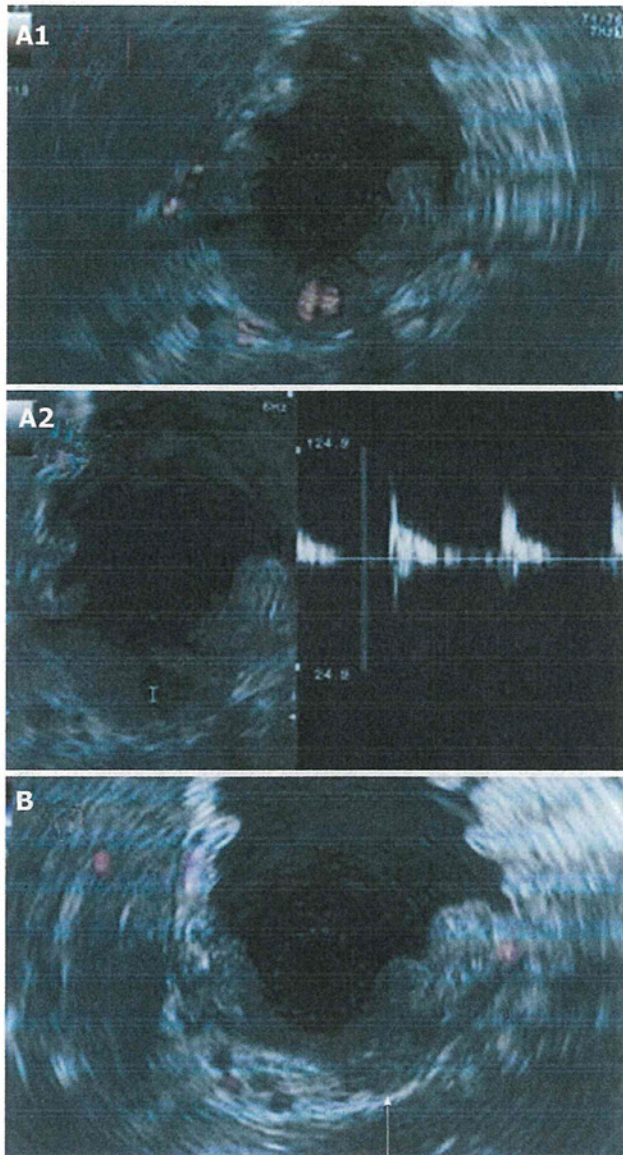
Endoscopic ultrasonography findings. A1: Endoscopic ultrasonography showed an anechoic region whose entire periphery was hypoechoic beneath the gastric mucosa. Power Doppler showed blood flow in the anechoic region. Upper gastrointestinal endoscopy showed a 2 cm, submucosal tumor-like protrusion with a red, eroded upper region located in the lesser curvature of middle of the body of the stomach (arrow); A2: Pulsed wave Doppler showed pulsatile blood flow in the anechoic region. This finding led to the diagnosis of an aneurysm; B: The cessation of blood flow to the pseudoaneurysm was confirmed with endoscopic ultrasonography which was performed 1 wk after treatment (arrow).
